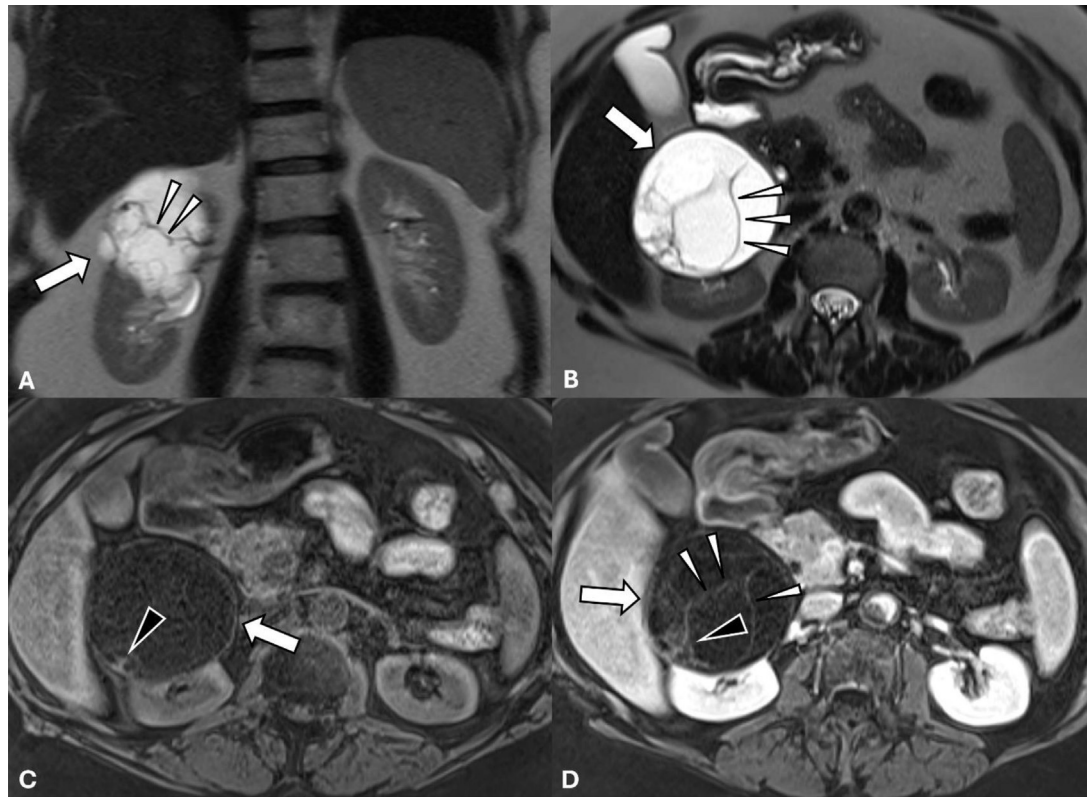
Coronal T2 (A), axial T2 (B), axial T1 precontrast (C) and postcontrast (D) MRI abdomen demonstrates a complex, multiseptated, partially exophytic, cystic lesion (arrow) in the interpolar right renal with enhancing septations (white arrowhead) along the right posterior lateral border of the lesion. Early mural nodularity is also noted along the right lateral border (black arrowhead).
